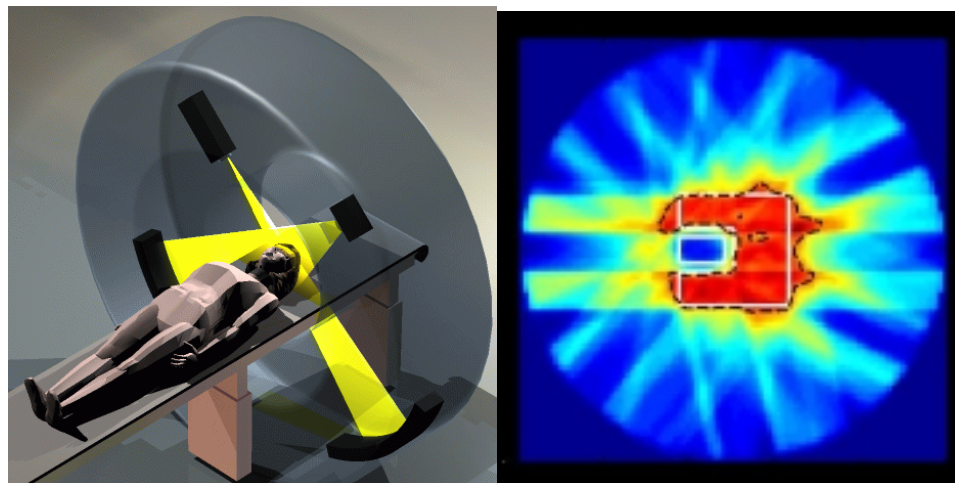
Future Tomotherapy machine allows “slice by slice” therapy with on-board spiral CT imaging. The complex dose distribution on the right shows pattern of high dose wrapping around a lower dose region. Clinically, this could be useful for tumours which surround the spinal canal. (Photos courtesy of T.R. Mackie, TomoTherapy Inc, Madison, WI). See reference 11.
